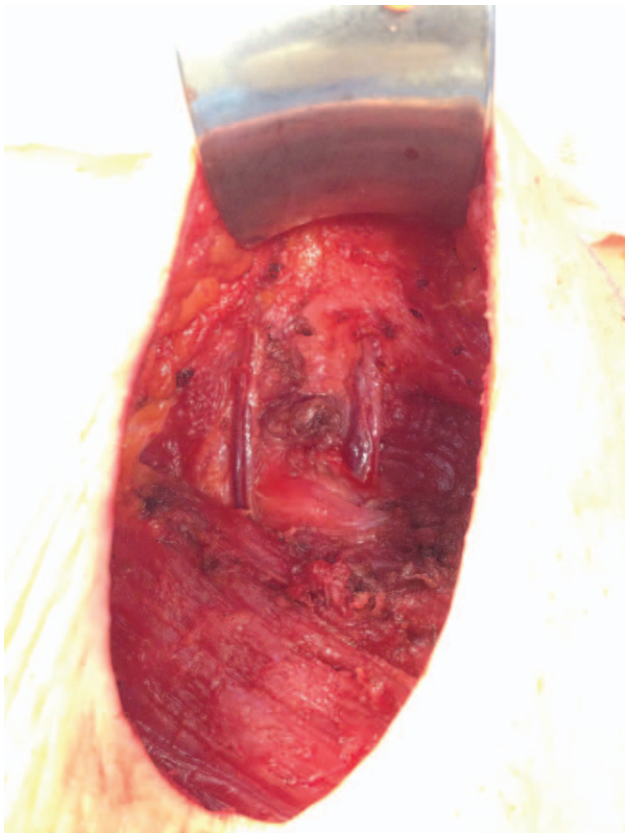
Two parasternal perforator vessels above and below the third rib, left breast after mastectomy.
